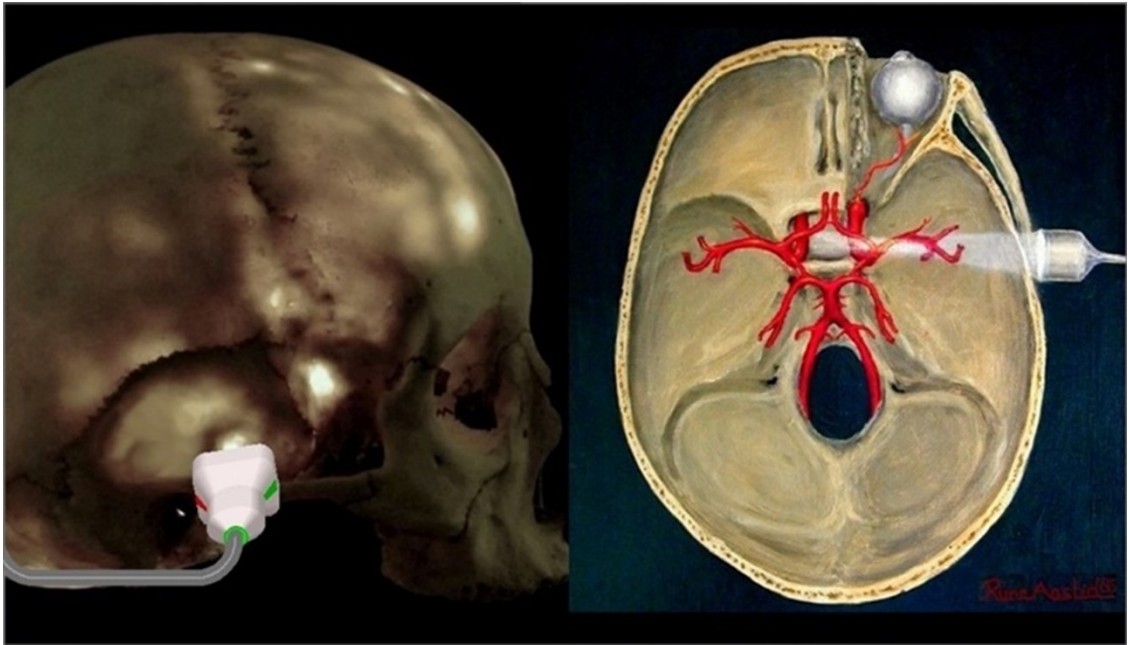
Transcranial Doppler ultrasound (TCD) transducer insonating a cerebral artery
